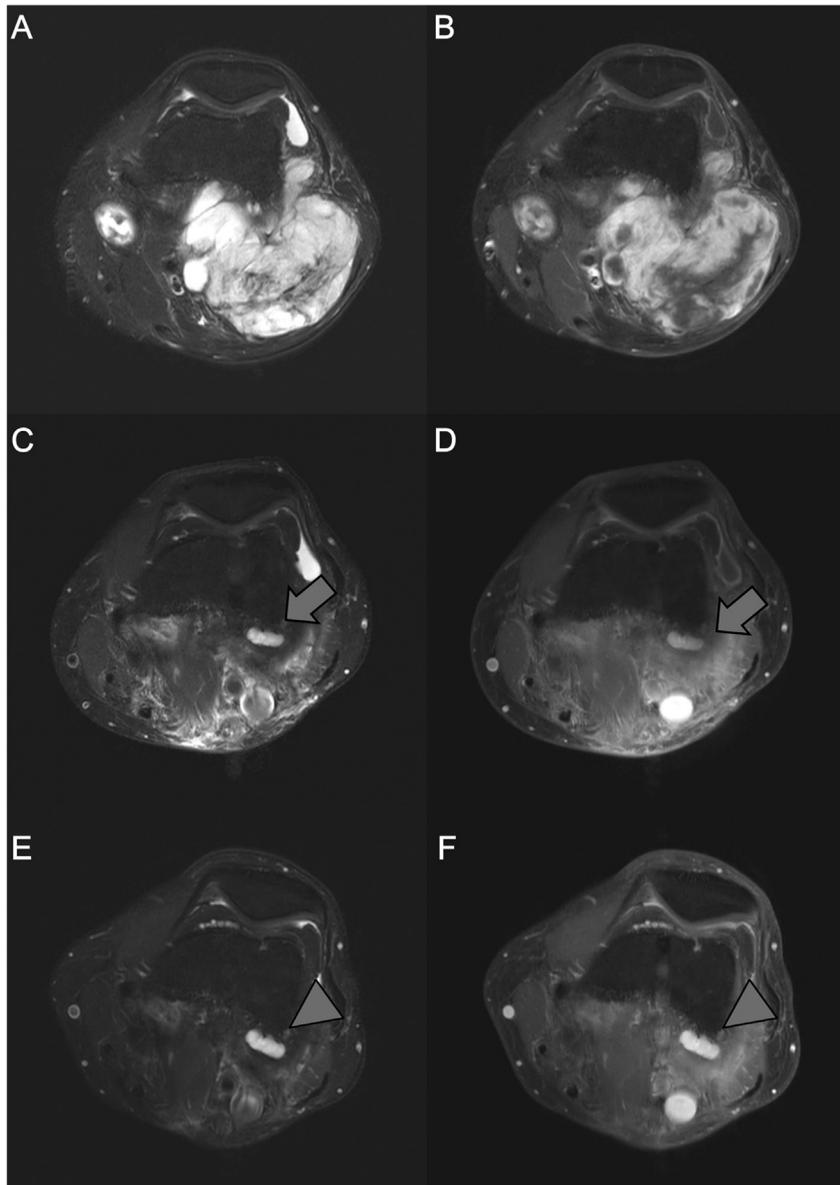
Representative case of MRI-detected local recurrence. A 55-year-old man with extraskeletal myxoid chondrosarcoma in the posterior thigh was diagnosed of small local recurrence. A and B, Preoperative axial MRI shows a large multi-lobulated soft tissue mass in posterior thigh. C and D, At postoperative 12 months, a small T2 hyper-intense enhancing lesion was detected at the lateral supracondylar area (arrows). E and F, On follow-up MRI 3 month later, the lesion increased in size (arrowheads) and was confirmed as local recurrence by biopsy. A, C, E: T2-weighted images, B, D, F: Gadolinium-enhanced T1-weighted images.
